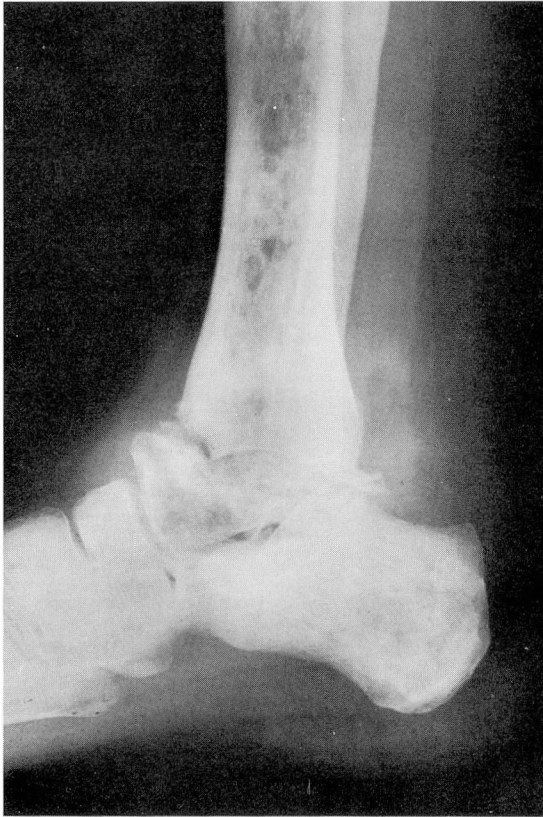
Roentgenogram of the right ankle with evidence of a pathologic fracture of the talus and, in addition, multiple small radiolucent defects in the tibia, the fibula, and the bones of the foot.
